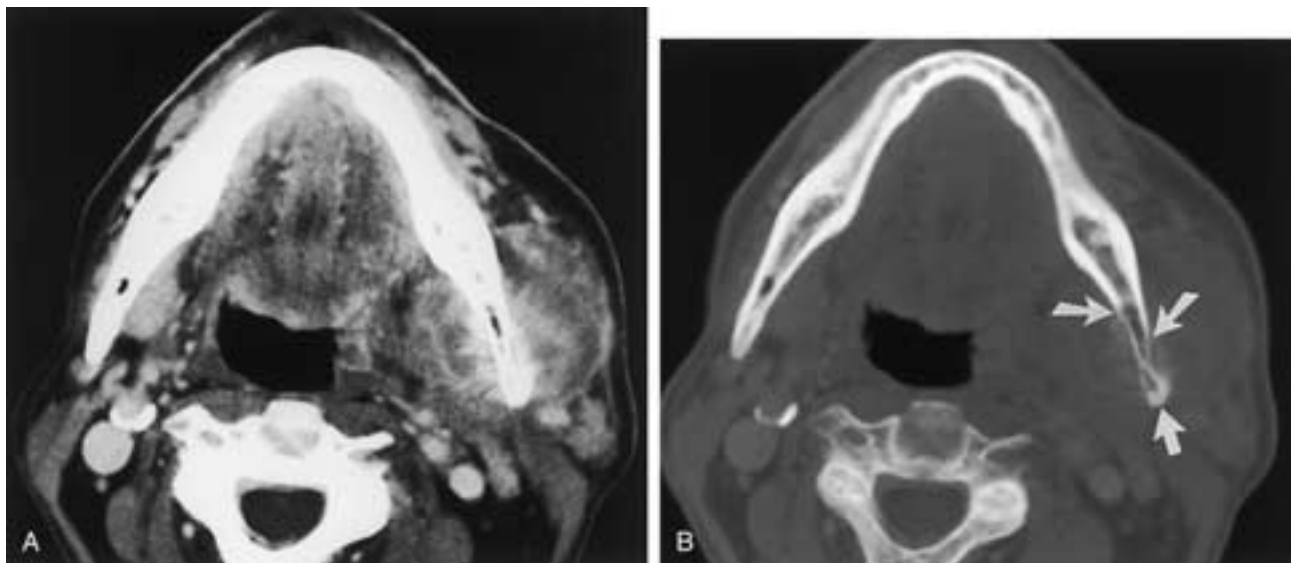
Metastatic rectal carcinoma to the left mandible. Axial contrast-enhanced CT scans in (A) soft-tissue and (B) bone windows reveal a destructive lesion of the left mandible extending through both the lingual and buccal cortices to involve the medial pterygoid and masseter muscles. There is a spiculated appearance that is very similar to that of the osteosarcomas demonstrated in [Figures 27-116B](#) and [27-116D](#). The cortical destruction is best appreciated on the bone window image (*arrows* in B), but the spiculation is very faint. (Courtesy of Dr. Deborah Reede.)
